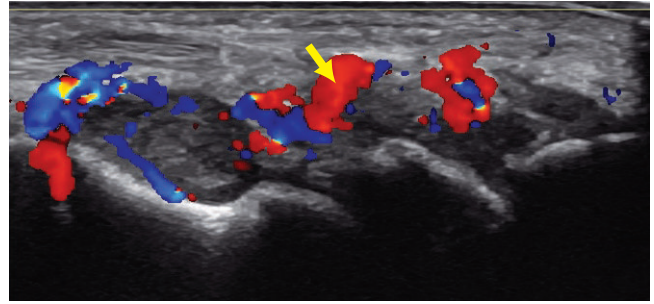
The longitudinal image of the dorsum of the wrist shows marked hypoechoic synovial thickening and increased color Doppler flow (arrow), which indicates synovitis.
